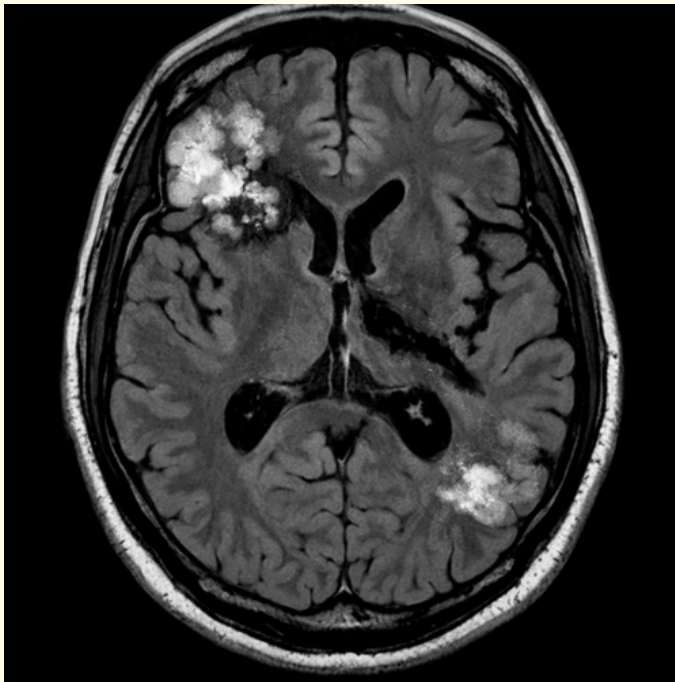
MRI of the brain showing an infarct and thrombosis.
